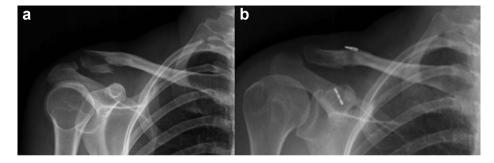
(a and b) Preoperative and 6-month postoperative anteroposterior X-ray views of a 34-year-old female patient.
